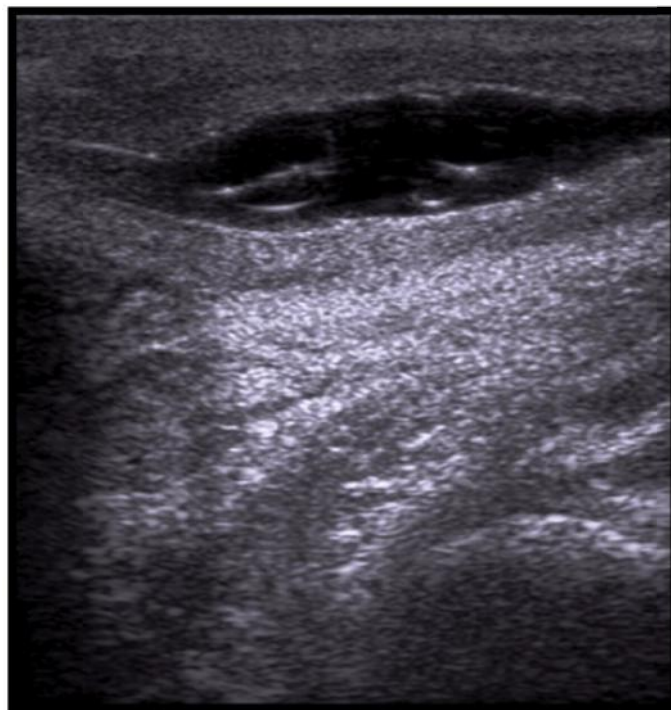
Sonographic imaging of stricture proximal bulbar urethra
